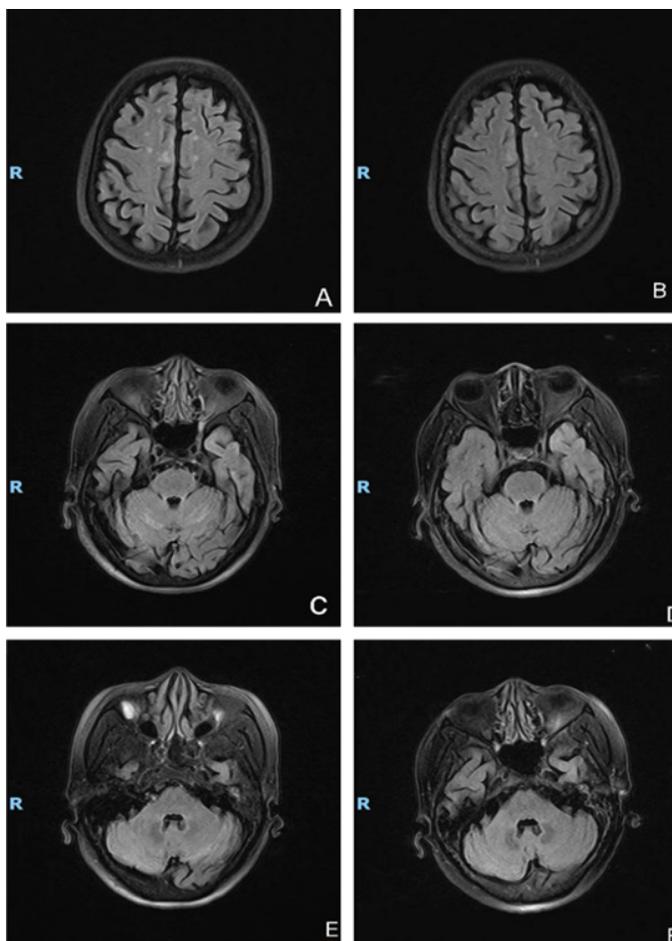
Serial cranial magnetic resonance imaging (MRI) of a patient with vitamin B12 deficiency-induced metabolic encephalopathy, before and after treatment.
